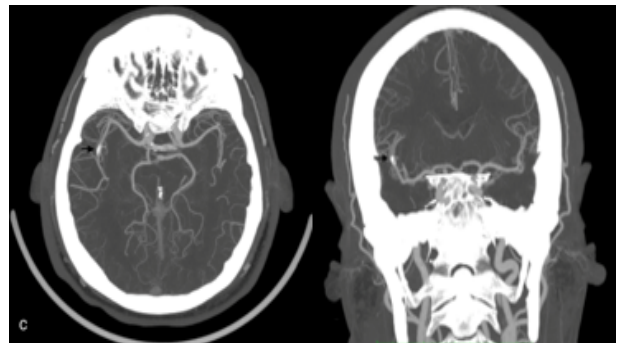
CTA Brain showing fusiform dilatation of the right M2 segment (arrow)
